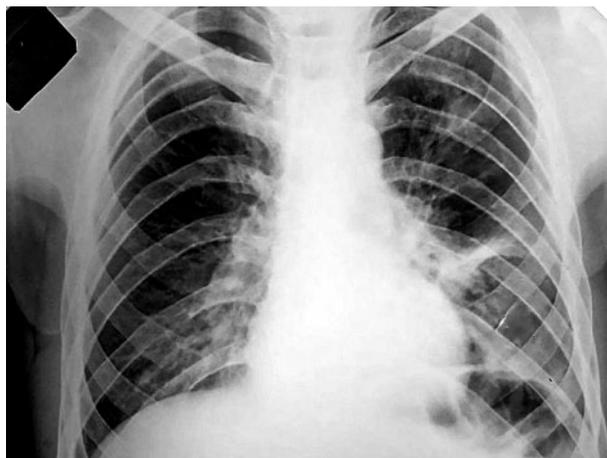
A36-year-old man; chest X-ray a six-month after the end of anti-tuberculosis treatment shows negative changes the form of an intense shadow in the the 3rd intercostal space of the left lung extending to the pulmonary root
